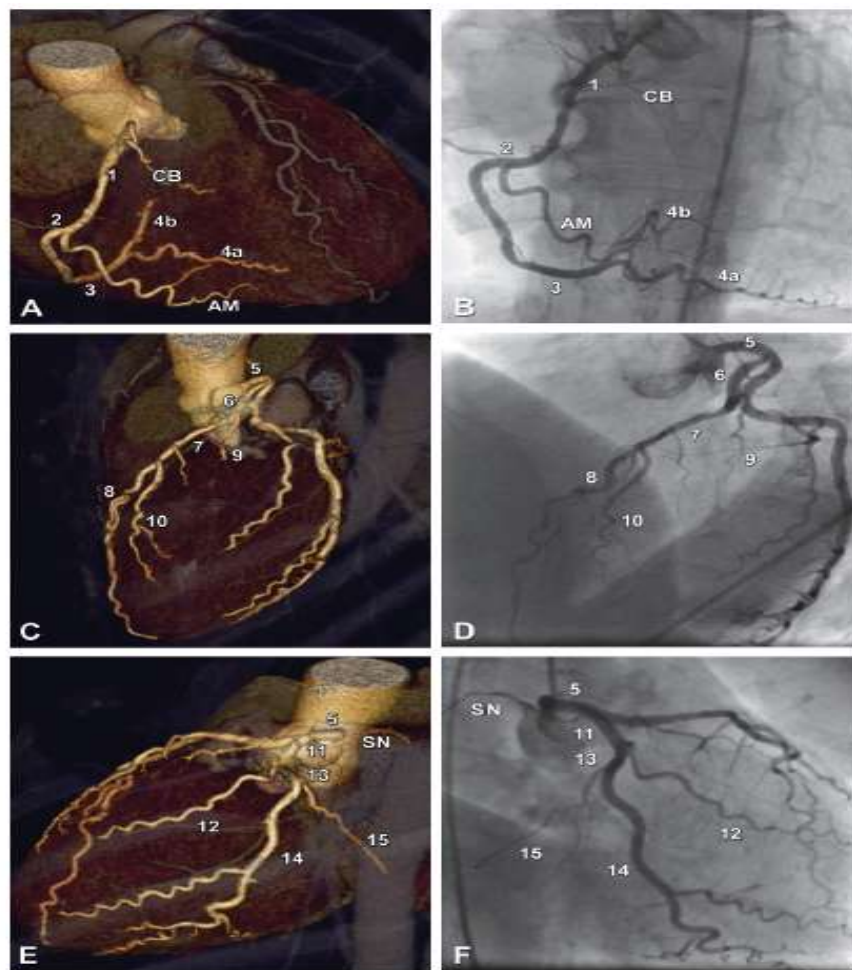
Direct comparison of segmental coronary artery anatomy, as depicted by multislice CT (*left panels*, three-dimensional reconstructions) and conventional coronary angiography (*right panels*). The RCA is shown in Panels A and B, and the left coronary artery with its two main branches – the left anterior descending and the left circumflex – in Panels C–F. The RCA (Panels A and B) is composed of segments 1–4, with the distal segment (4) being further subdivided into 4a (posterior descending artery) and 4b (right posterolateral branch). The left main coronary artery (Panels C–F) is referred to as segment 5, and the left anterior descending coronary artery (Panels C and D) is composed of segments 6–10, with the two diagonal branches being segments 9 and 10. The LCX (Panels E and F) is composed of segments 11–15, with the two (obtuse) marginal branches being segments 12 and 14. Note that the distal left circumflex (segment 15) is rather small in this patient with a right-dominant coronary circulation. The sinus node artery (SN) is the first branch of the LCX in this patient (Panels E and F) but is more commonly one of the first branches of the RCA. AM acute marginal branch; CB conus branch (*Dewey, 2009*).
